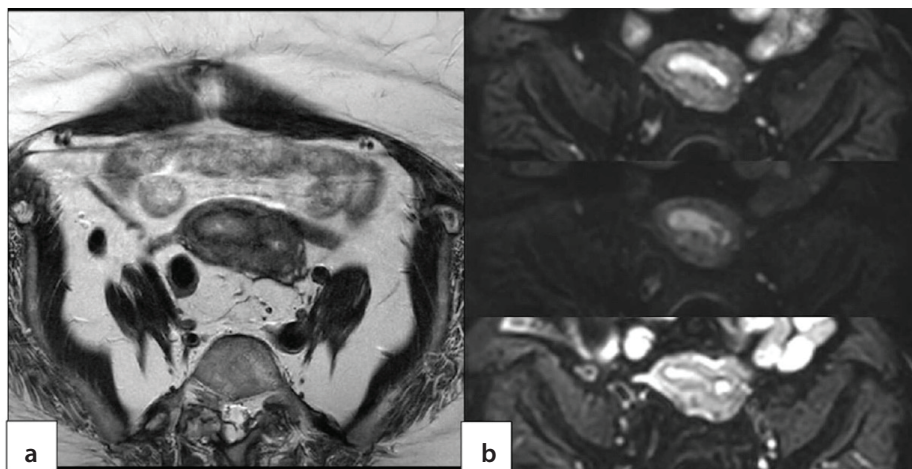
In a 54-year-old patient with a pathological diagnosis of grade 2 endometrial adenocarcinoma of the endometrioid type, a mildly hyperintense mass lesion is observed on T2-weighted oblique axial series (a), and a high signal intensity mass is seen on diffusion-weighted imaging (b), located in the right uterine horn and causing expansion at this level. Based on the MRI examination, the lesion was interpreted as not having DMI. However, the pathological evaluation revealed the presence of DMI. MRI, magnetic resonance imaging; DMI, deep myometrial invasion.
